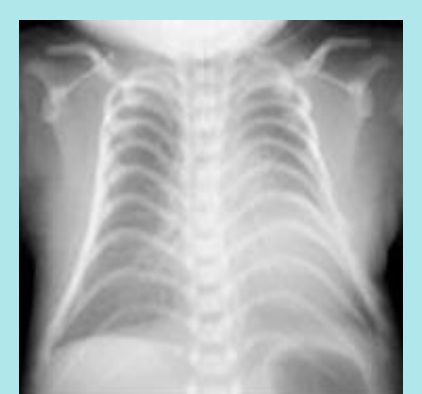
Chest radiograph showing increased coat-hanger angle to the ribs.
